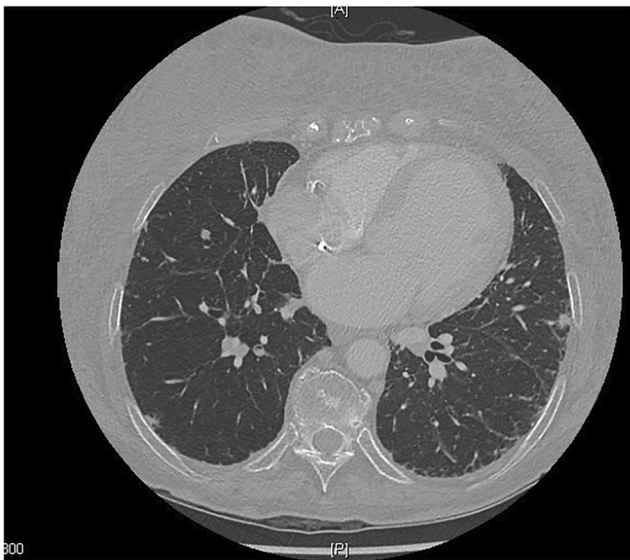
Pre-procedure chest CT scan
